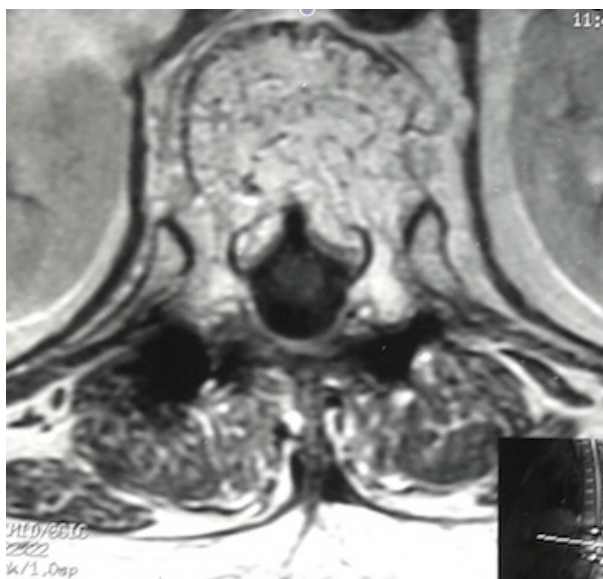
Axial MRI T2 image depicted that the lesion involved the vertebral body and spread into spinal canal.
